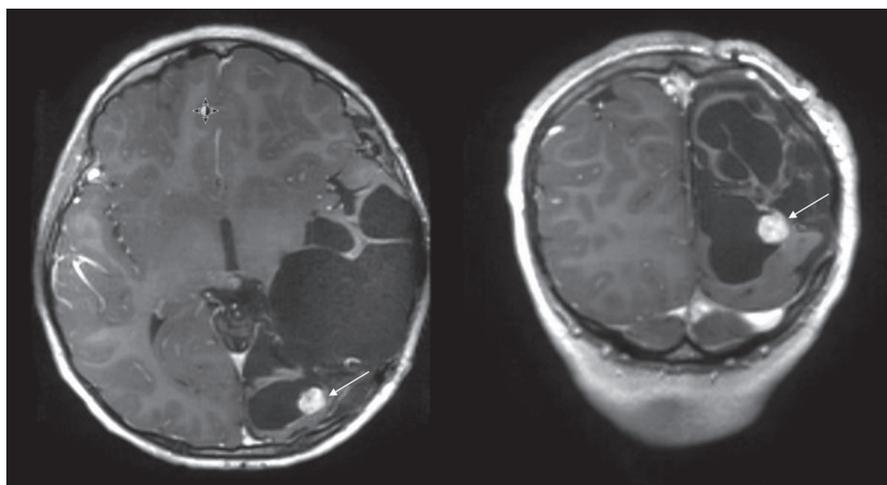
Recurrent mass in the resection cavity found on a routine surveillance MRI 7 yr and 2 mo after initial surgery.
